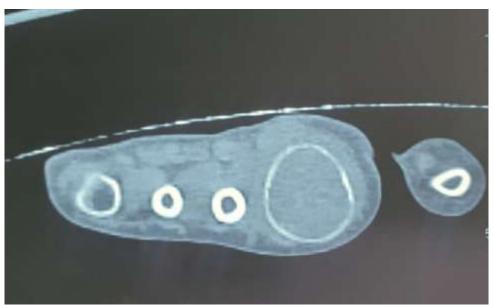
CT transversalimaging showing a distal mass of the 2nd left metacarpal.
